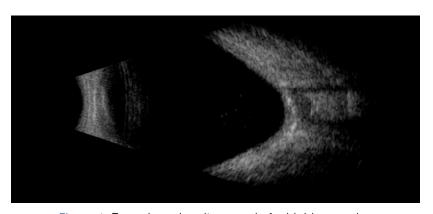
B-modeocular ultrasound of a highly myopic eye
